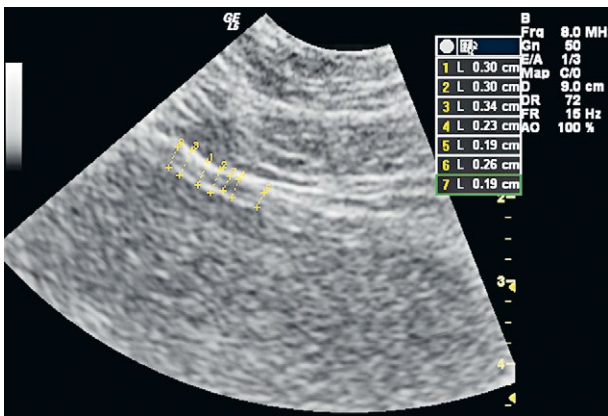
Ultrasonographic image of bladder wall using an 8.0 MHz probe and measurement of bladder wall thickness (measurements 1-3) and detrusor wall thickness (measurements 4-7).
